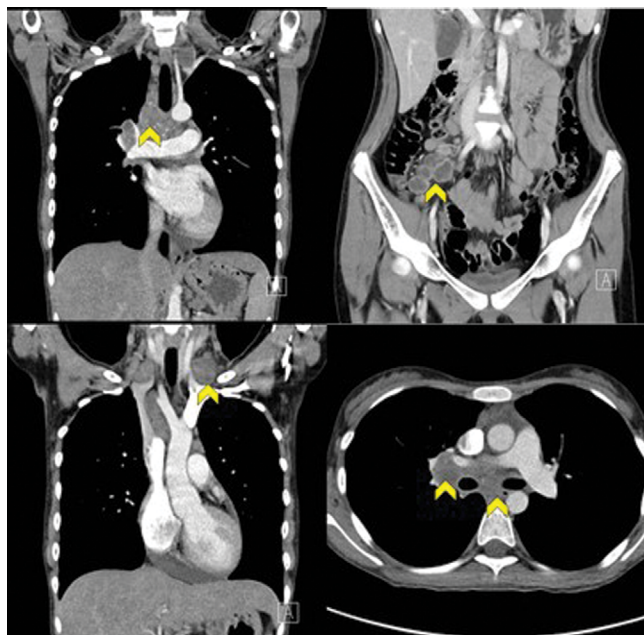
Computed tomography scan with coronal and transverse views showing multiple enlarged and necrotic lymph nodes
